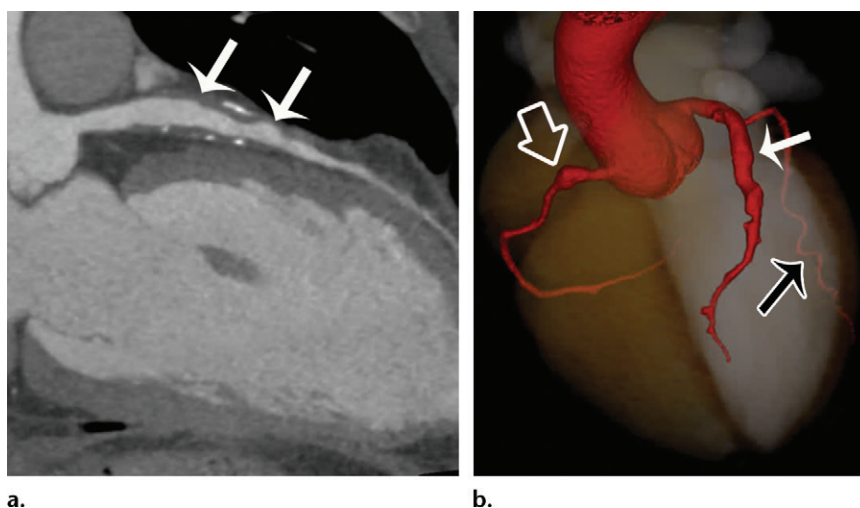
Fusiform aneurysmal dilatation in a 17-year-old adolescent girl with a remote history of KD. (a) Curved planar reformation from coronary CT angiography along the LAD shows a giant (14-mm internal diameter) coronary arterial aneurysm with extensive long-segment fusiform aneurysmal dilatation of the LAD (arrows) with eccentric mural thrombus, containing calcifications. (b) Three-dimensional volume-rendered image shows extensive fusiform dilatation (solid white arrow) of the LAD and a more focal fusiform aneurysm (open white arrow) of the proximal RCA. The LCx (black arrow) courses behind the left ventricle on this view.
